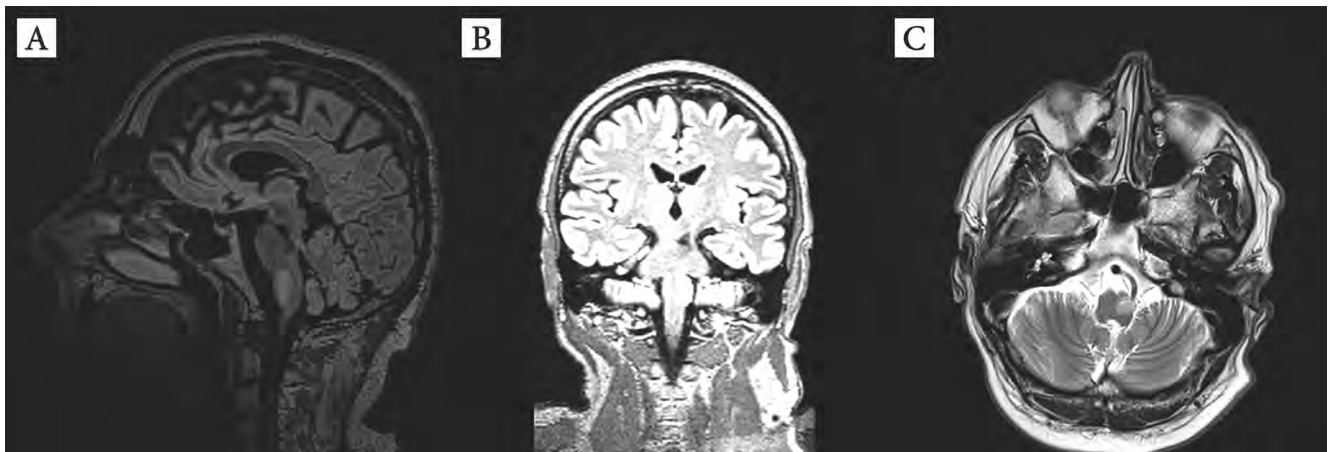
Brain MRI performed 16-months after the brainstem haemorrhage showing hyperintensity and enlargement of the inferior olivary nucleus, ponto-mesencephalic hypointensity consistent with the old haemorrhage.
